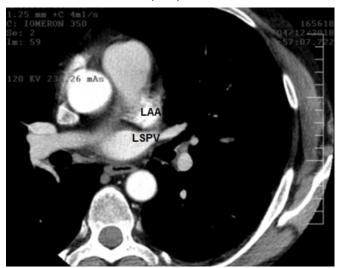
Computed tomography of the heart. Left atrial appendage and left superior pulmonary vein. LSPV has an anterior orientation.
